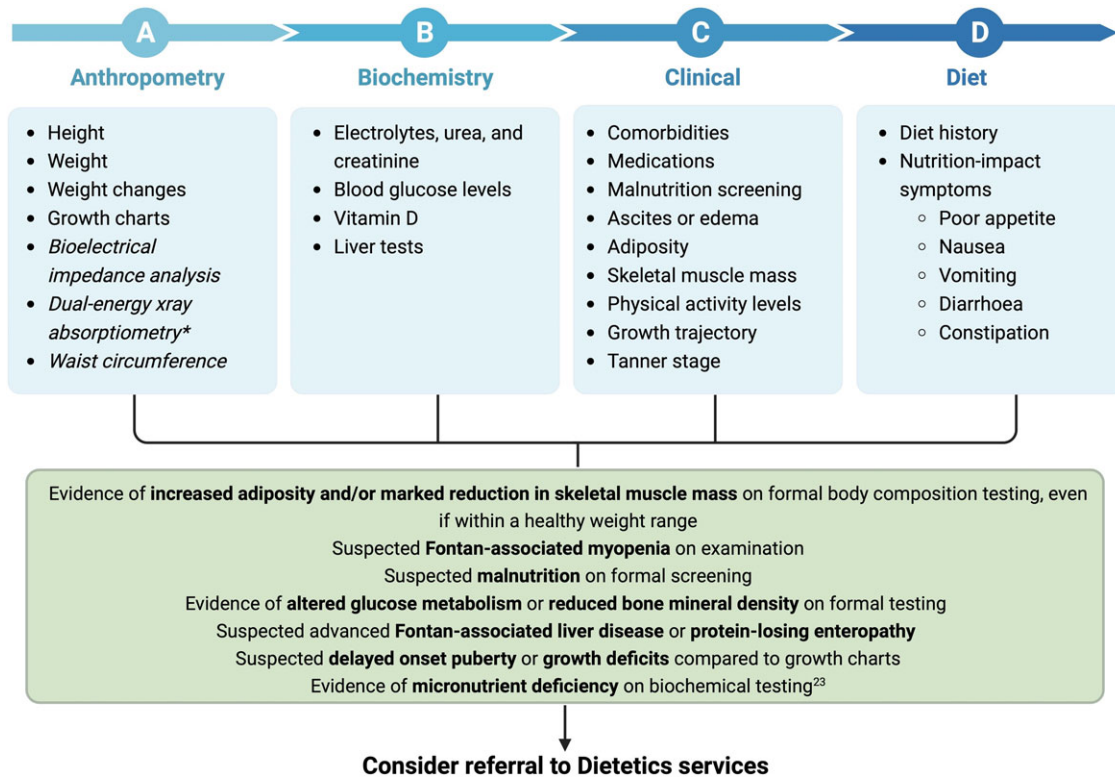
Clinical framework for nutrition assessment of paediatrics with a Fontan circulation. Unestablished tests are in italics. *Dual-energy X-ray absorptiometry provides small radiation exposure. Created with Biorender.com.
